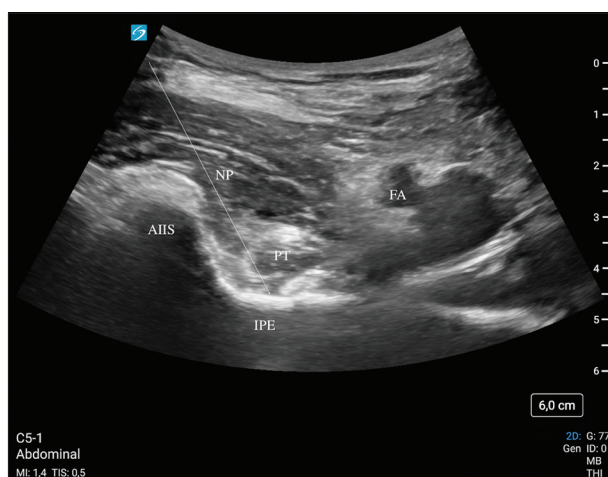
Ultrasound image of the Pericapsular Nerve Group block: NP, needle path; IPE, iliopubic eminence; FA, femoral artery; PT, psoas tendon; AIIS, anterior inferior iliac spine
